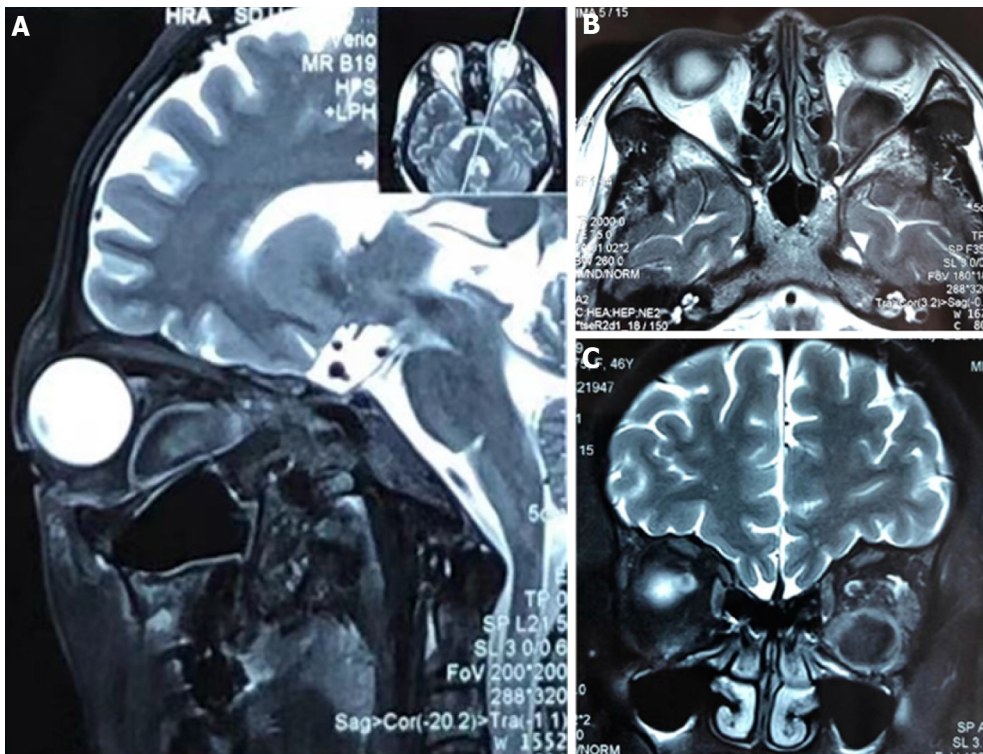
Magnetic resonance imaging scans of orbits. A-C: Magnetic resonance imaging scans of orbits showed that the left eye was protruding, and an elliptical long-short T1 long-short T2 signal focus was observed in the lateral optic nerve of the left orbital muscle cone, with smooth edges and low signal on DWI. The left hyperdense retrobulbar mass displaced optic nerve superomedial.
